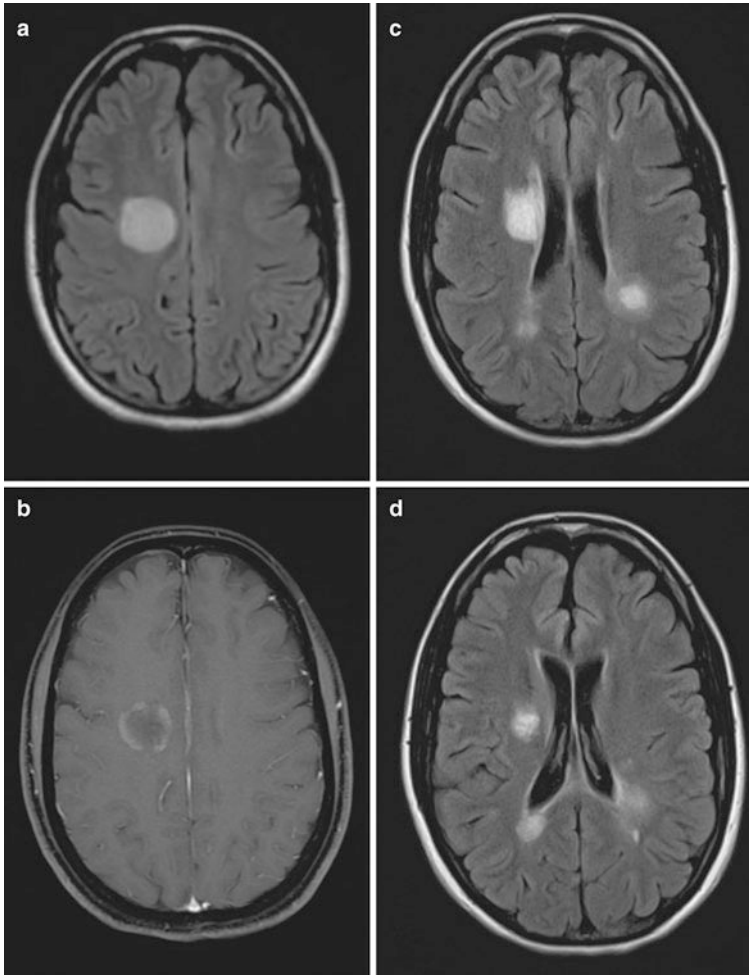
Natalizumab-associated IRIS versus PML. A 28-year-old with multiple sclerosis had been on natalizumab for 2 years. Drug was discontinued in anticipation of conception, but after 4 months without established pregnancy, a follow-up scan at a time when the patient was asymptomatic showed a large FLAIR abnormality with partial ring enhancement (a, b). Seventeen days later the patient developed Gerstmann syndrome. The right hemisphere lesion no longer enhanced, but new lesions had developed in the left hemisphere and corpus callosum (c, d). In panel (c), the left hemisphere lesion shows concentric circles of hyperintensity consistent with demyelination. The differential diagnosis was PML versus natalizumab withdrawal-associated IRIS. JCV was negative in the CSF, and patient recovered completely after high-dose corticosteroid treatment. Natalizumab treatment has been resumed for more than 1 year without complication usually hypointense on T1 and hyperintense on T2-weighted imaging compared to the normal white matter. Signal intensity and CT attenuation changes are subject to temporal changes. The subcortical arcuate (U) fibers are typically involved at first, creating sharp, scalloped margins (Fig. 14.1b, c). Rarely, faint marginal contrast enhancement may be encountered, particularly in the acute phase of demyelination. In HIV patients receiving antiretroviral therapy (HAART), marked enhancement can be observed, particularly during the immune reconstitution syndrome [8]
